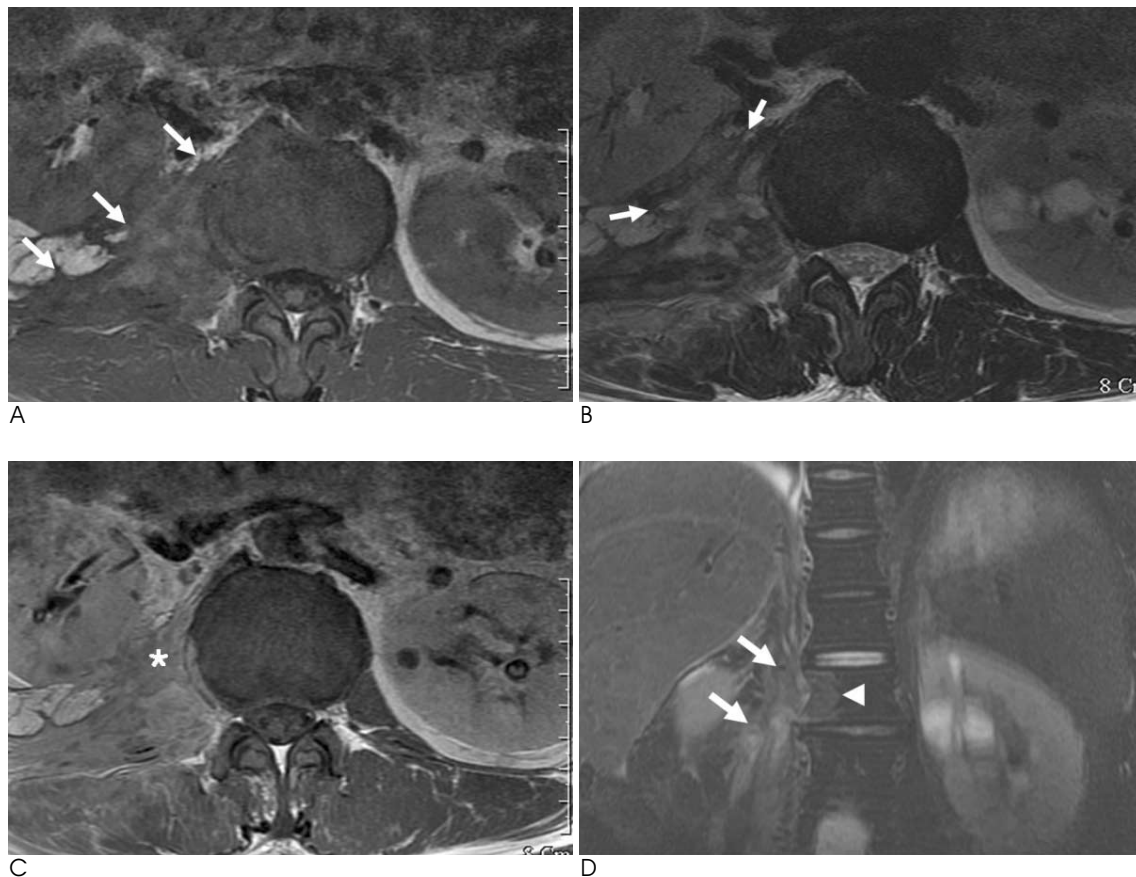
A. The axial T1-weighted image (TR/TE,666/9) showing a paraspinal mass (arrows) with low signal intensity surrounding the right paravertebral margin of L1.
